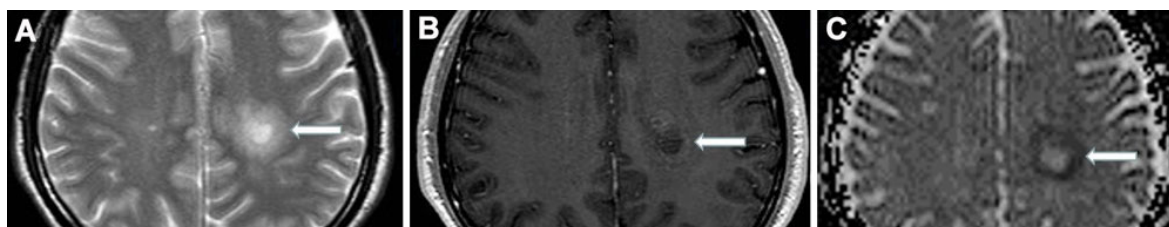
(A) Axial T2-weighted image reveals a high signal lesion in the centrum semiovale; (B) axial T1-weighted image shows mild enhancement after contrast administration; (C) apparent diffusion coefficient map shows restricted diffusion at the periphery of the lesion
